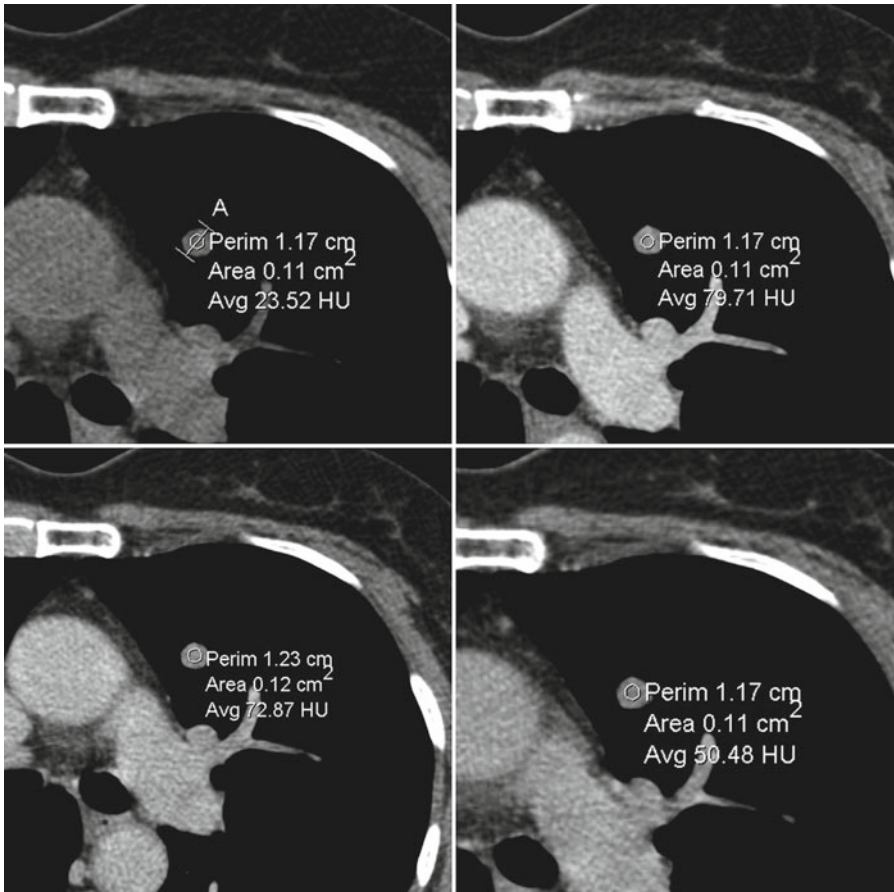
Nodule enhancement. Axial CT images without contrast and at 1, 2, and 4 min following contrast injection show peak enhancement of 56 HU, an indeterminate result. Nodule considered benign after 2 years of no growth
